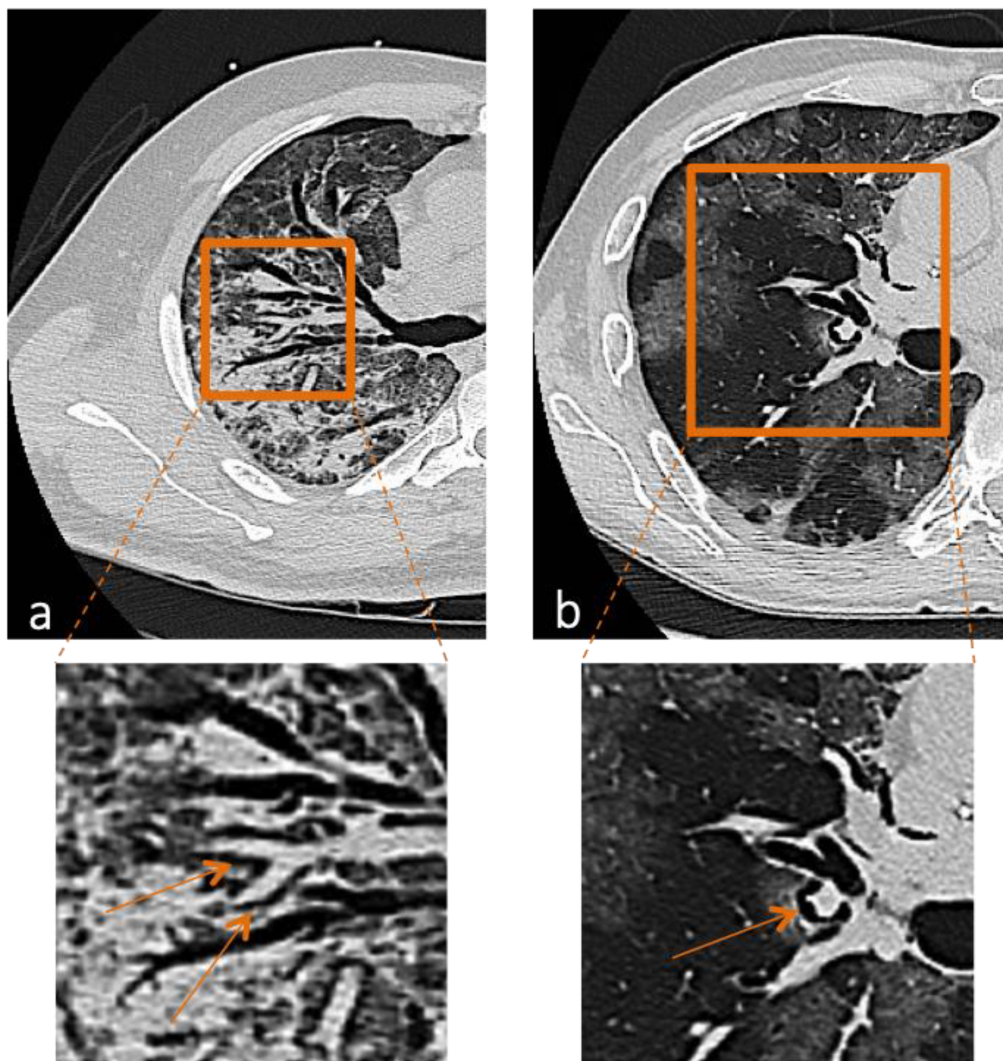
Chest CT scan of a patient with Macklin sign. (a) Macklin sign in mid-distal bronchovascular tree. (b) Macklin sign in proximal bronchovascular tree.
